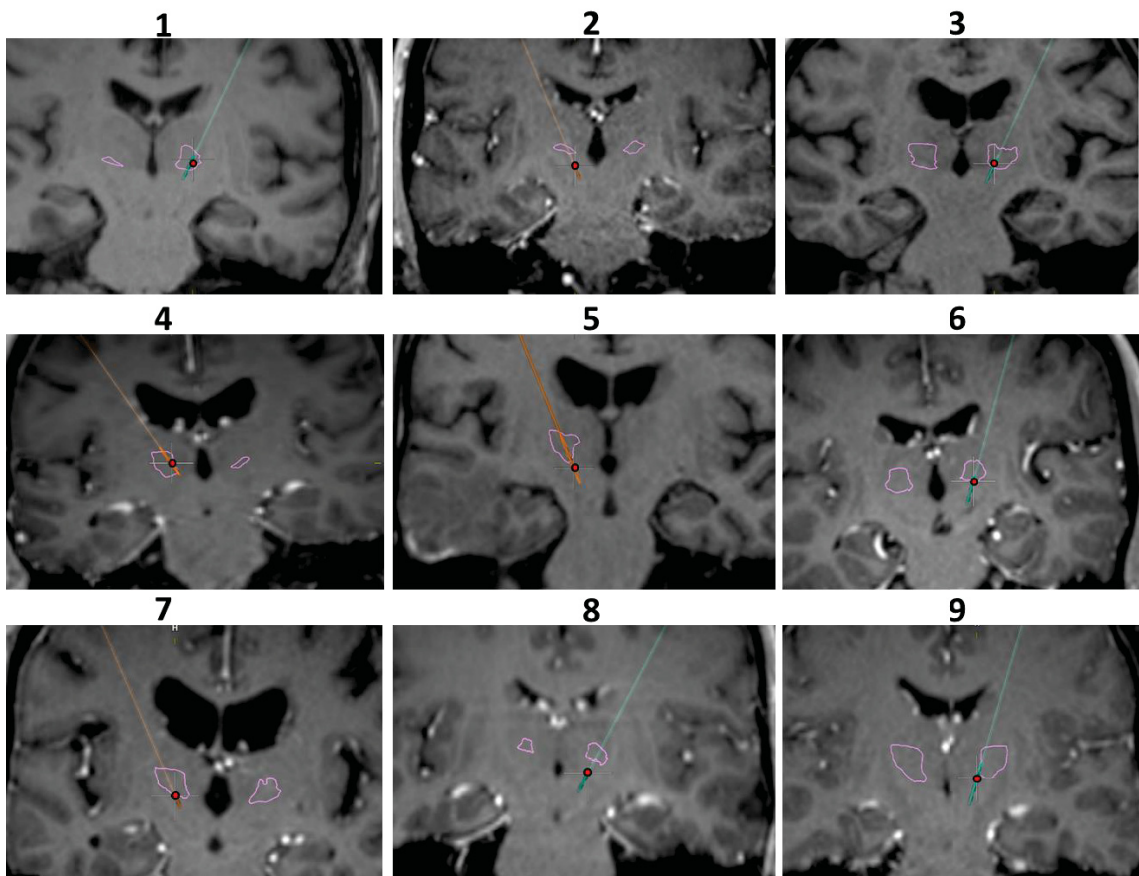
Postoperative MRI/CT fusion images corresponding to nine patients. (The figure belongs to a manuscript (94)).
